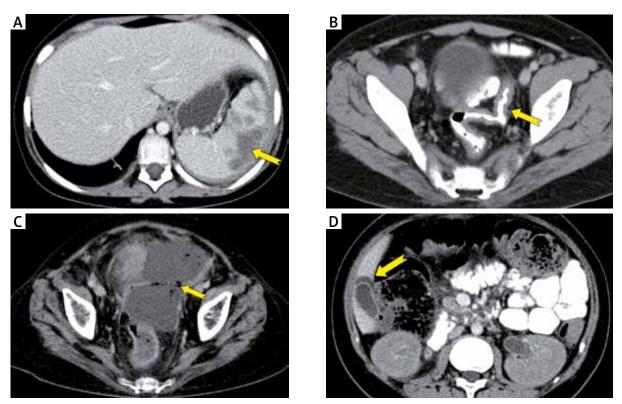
A–B) A 14-year-old boy with acute myeloid leukaemia. A) Axial CT image taken 76 days after haematopoietic stem-cell transplantation shows multiple splenic abscesses (arrow). B) Axial CT image demonstrates moderate mucosal enhancement of the sigmoid colon (arrow). The patient died of GVHD. C–D) A 17-year-old girl with thalassemia. C) Axial CT image performed 47 days after haematopoietic stem-cell transplantation reveals free intraperitoneal air and fluid collection (arrow) due to intestinal perforation. D) Axial CT image shows wall thickening and enhancement of gall bladder with pericholecystic fluid (arrow). The patient died of GVHD
